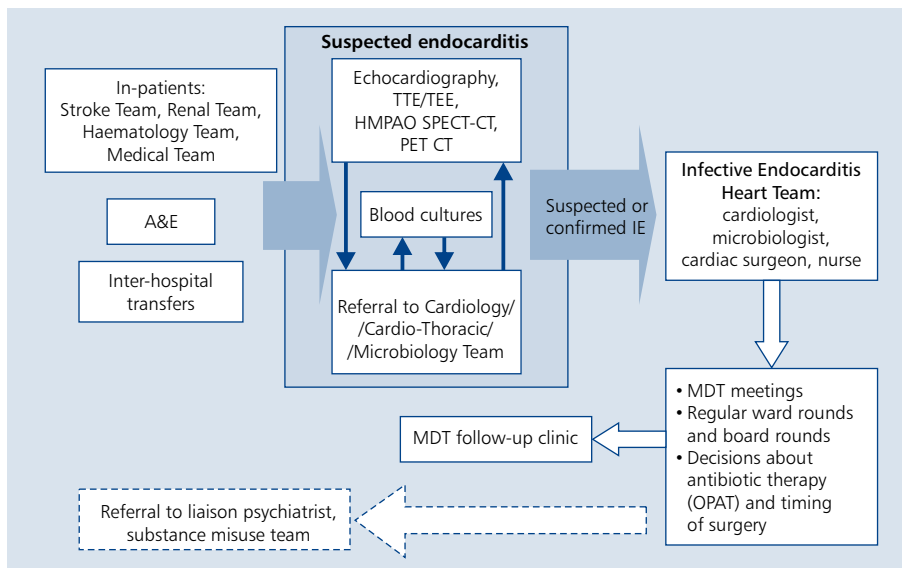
Referral pathway and journey of patients with infective endocarditis (IE); A&E — accident and emergency; MDT — multi-disciplinary team; OPAT — outpatient antibiotic therapy; PET — positron emission tomography; SPECT-CT — single-photon emission computed tomography; TEE — transoesophageal echocardiography; TTE — transthoracic echocardiography
